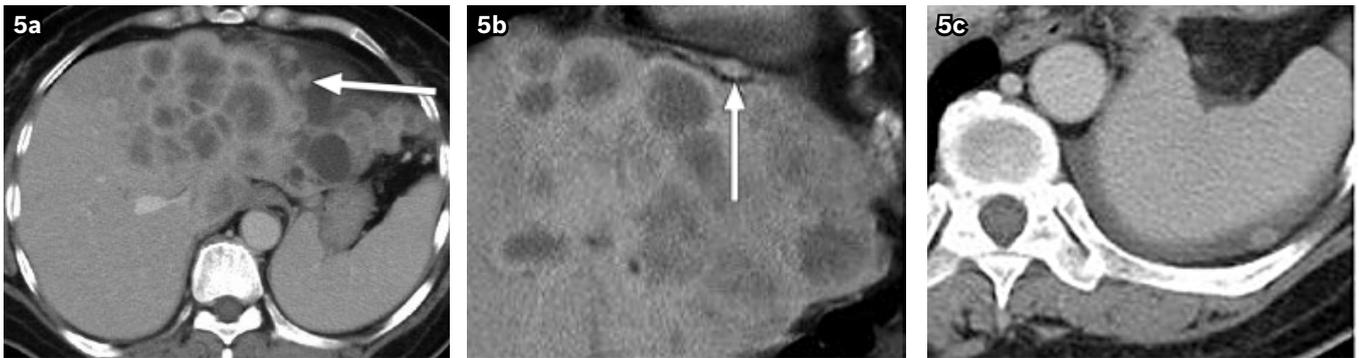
CT images show (a) a large liver lesion with rim-enhancement and multiple internal septa. Multiple enhancing nodules are seen adjacent to the capsular surface of the left lobe and the left hemidiaphragm (arrow); (b) well-demonstrated lesions by coronal reformat images (arrow); and (c) another small peritoneal nodule adjacent to the spleen.
